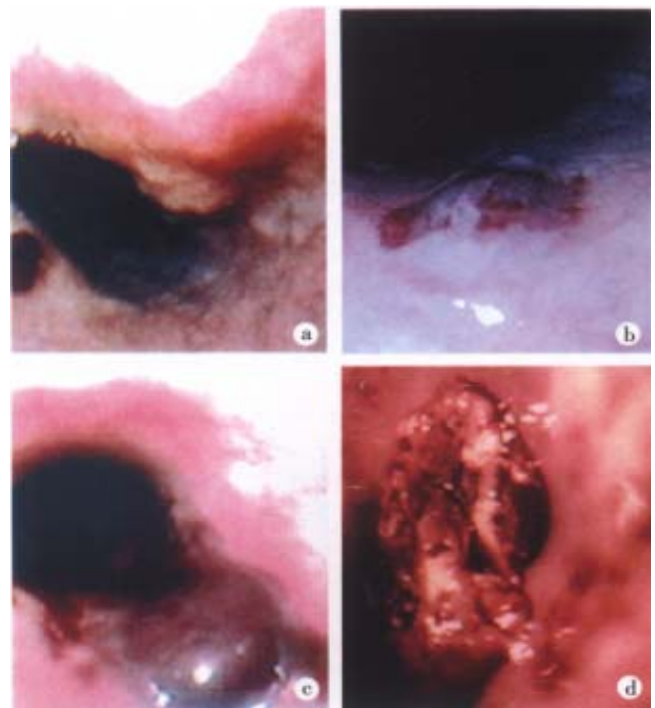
Endoscopic appearance of esophageal hematoma as. a: Stage I esophageal hematoma. There is no surrounding edema. Patient was asymptomatic. b: Stage II esophageal hematoma after an esophageal biopsy. Note the surrounding tissue edema. c: Stage III hematoma induced by esophageal dilation of a stricture. There is edema and separation of the surface mucosal layer that is partially obliterating the lumen. Patient was asymptomatic. d: Stage IV esophageal hematoma related to recent transesophageal echocardiography. Edema and clot formation led to complete obliteration of the esophageal lumen and hematemesis.
